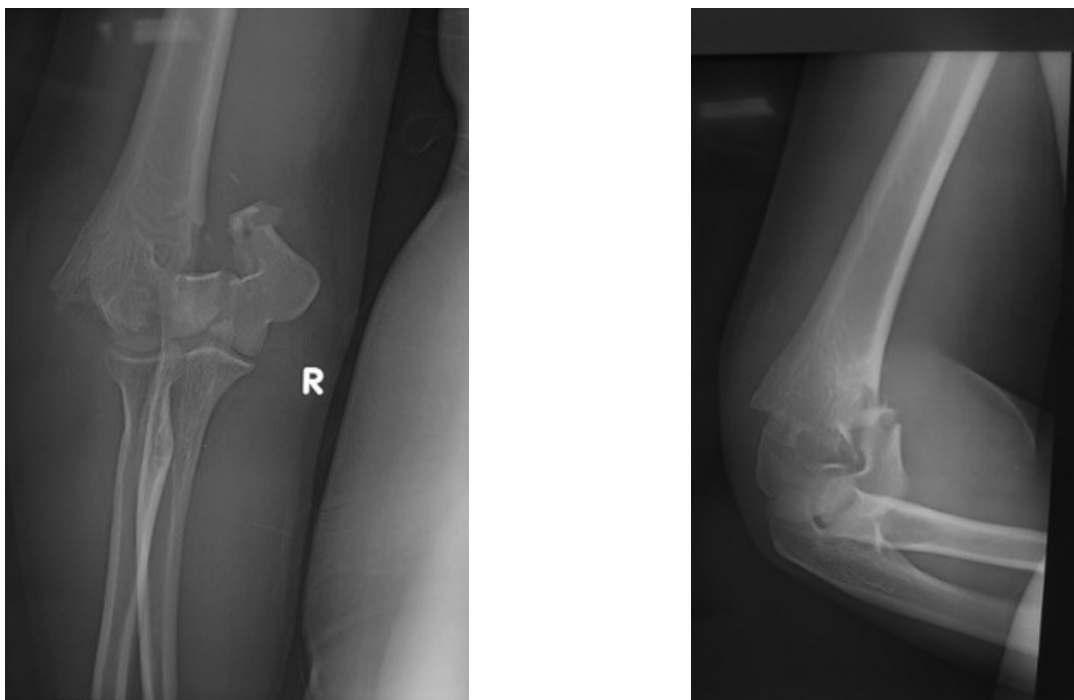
Pre-op radiographs of Type C AO distal humerus fracture
